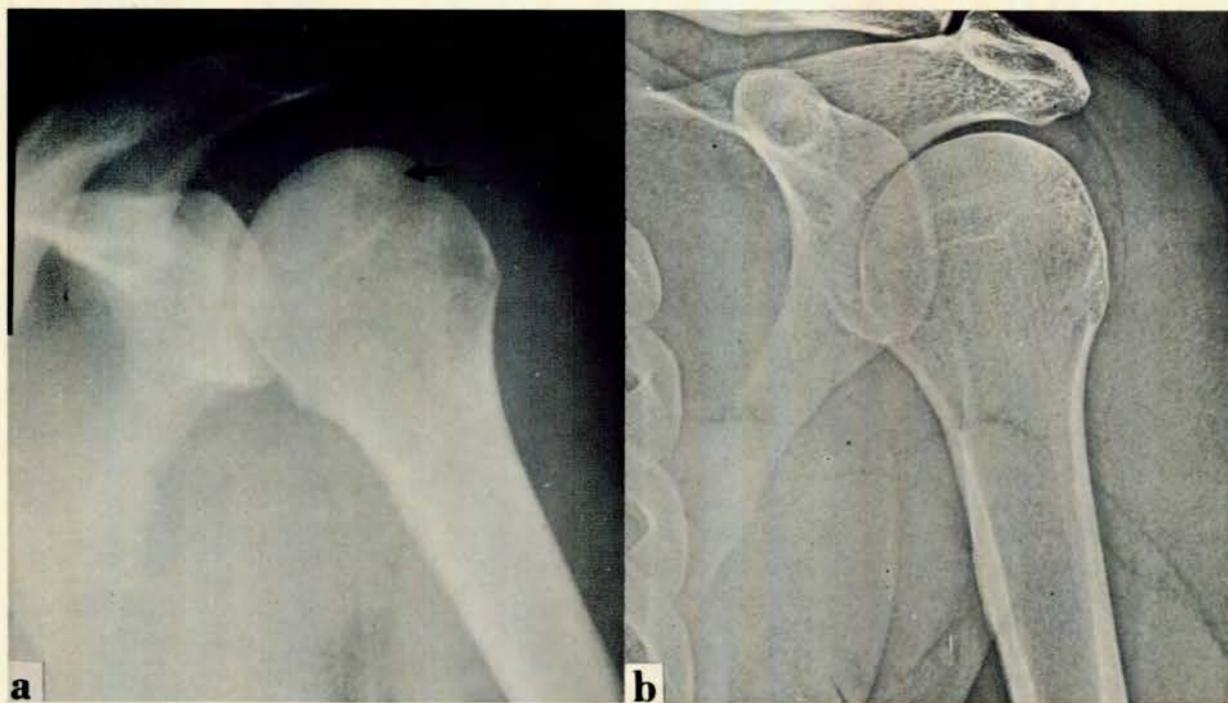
(a) Subtle area of osteonecrosis (arrow) in juxta-articular area of R humerus of diver, as demonstrated roentgenographically. (b) Lesion is not evident on xeroradiogram.
